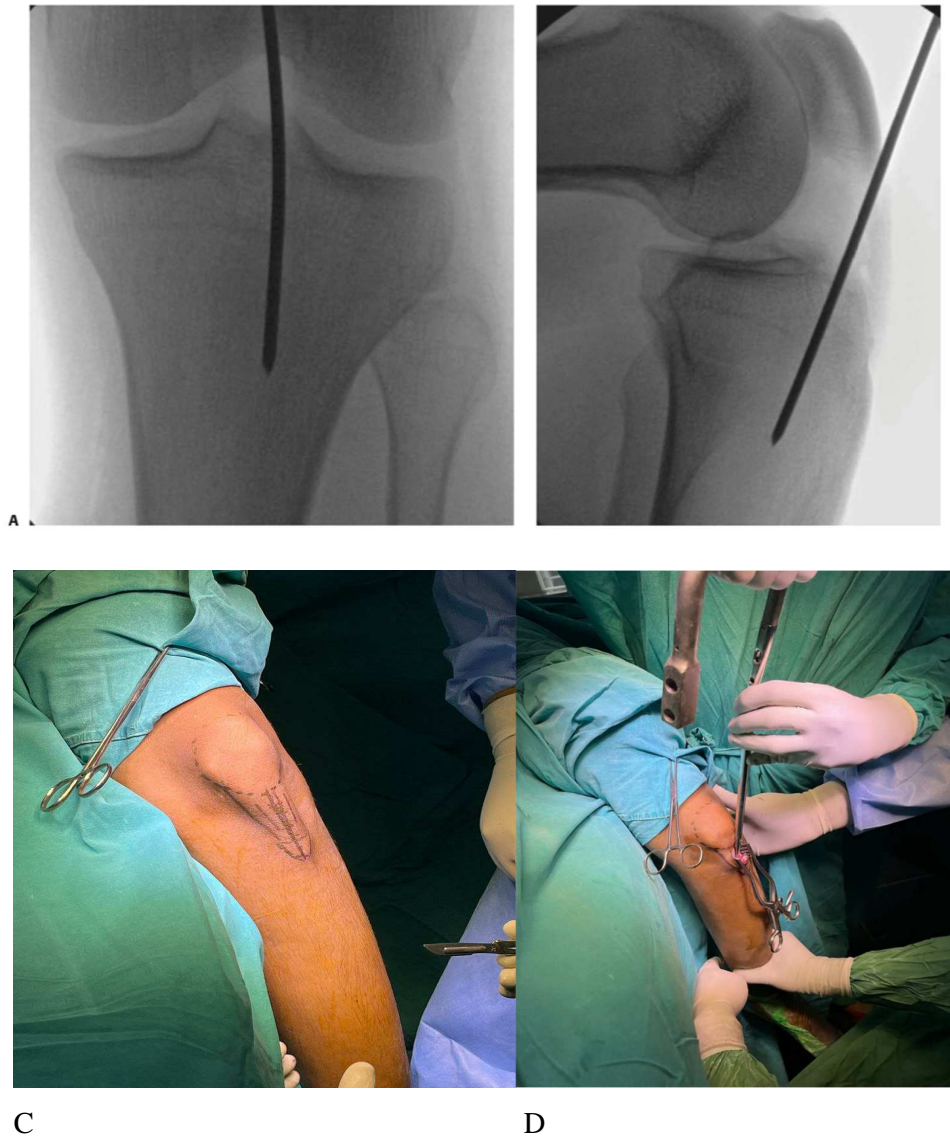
(A) and lateral (B) radiographs of the knee demonstrating the placement of a starting wire (C) hyperflexed position of knee during infrapatellar nailing (D) hyperflexed positioning while passing the nail.
